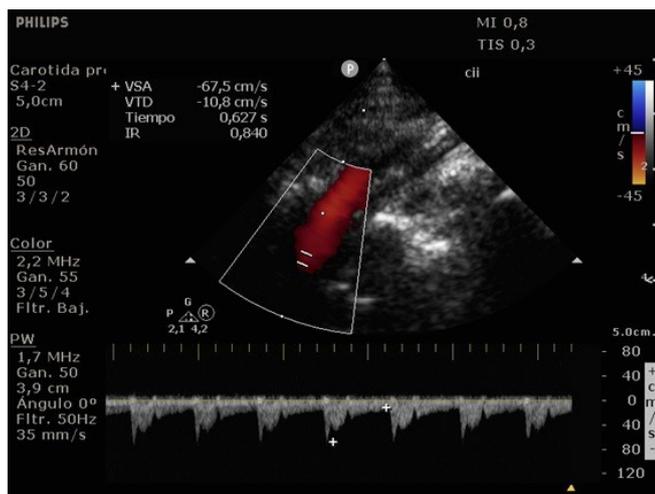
Internal carotid artery conventional ultrasonography.
